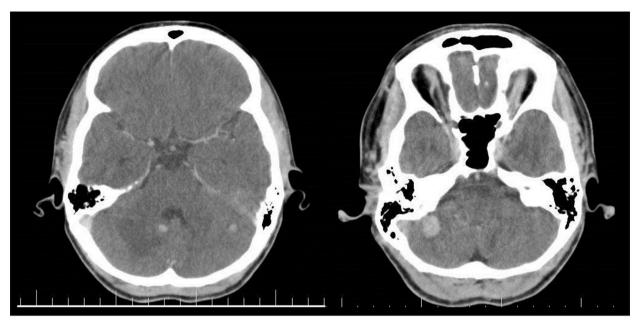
Contrast-enhanced brain CT showing solid and enhanced nodules in the cerebellum with a large lesion (20 mm) in the right jugular fossa with extension to the cerebellopontine angle.
